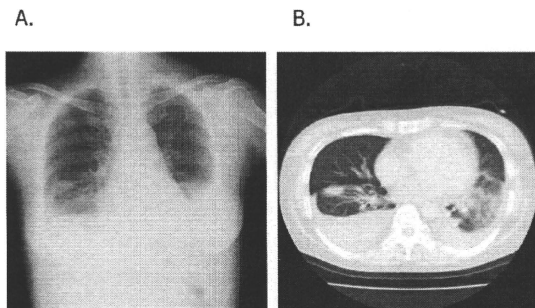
A) Chest X-ray film shows hypolucence in the bilateral lower lung fields on January 16th, 2006.
